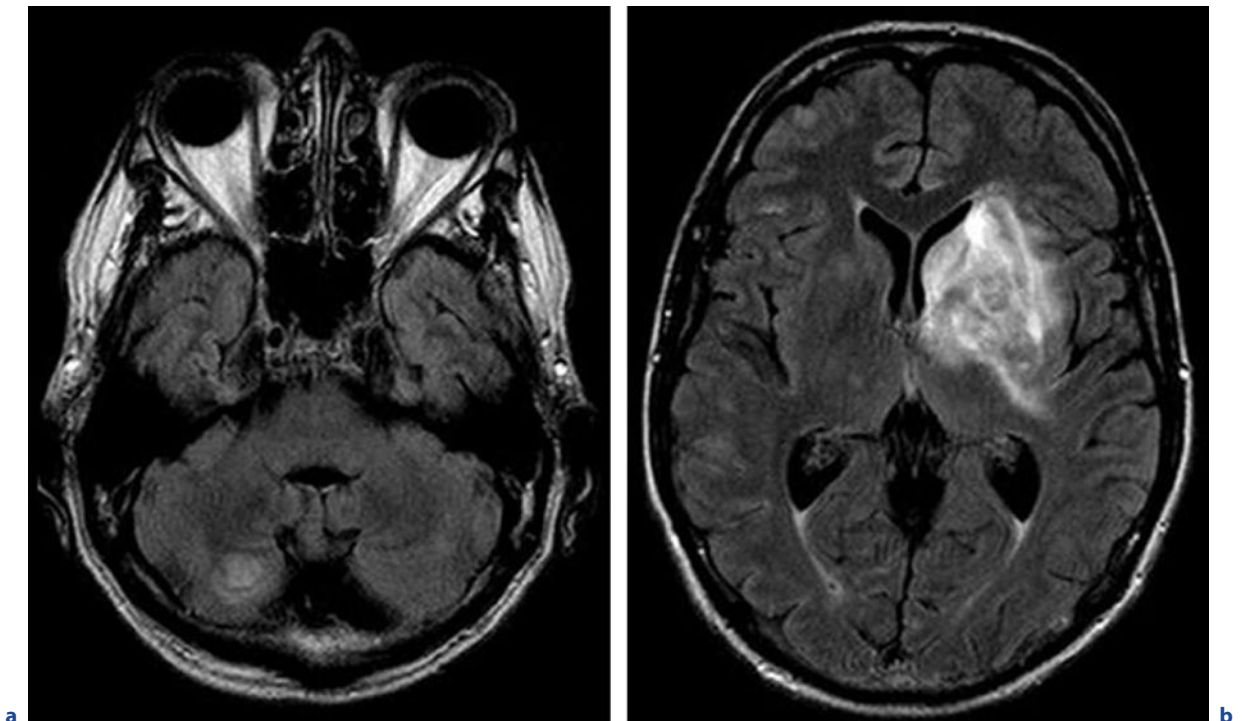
Cerebral toxoplasmosis in an immunocompromised 56-year-old man. a,b Axial FLAIR images. c-f see next page
